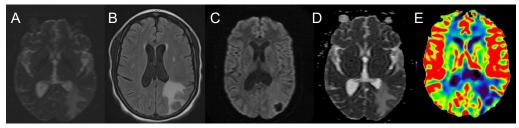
Brain MRI revealing left parietal intracranial lesion. The lesion shows hypointensity on T2/ FLAIR (images A and B). Of note is the characteristic pattern of diffusion restriction (images C and D), as well as the absence of perfusion (image E). A. Axial T2 Sequence; B. FLAIR Axial Sequence; C.DWI; D. ADC map.; E. Perfusion
